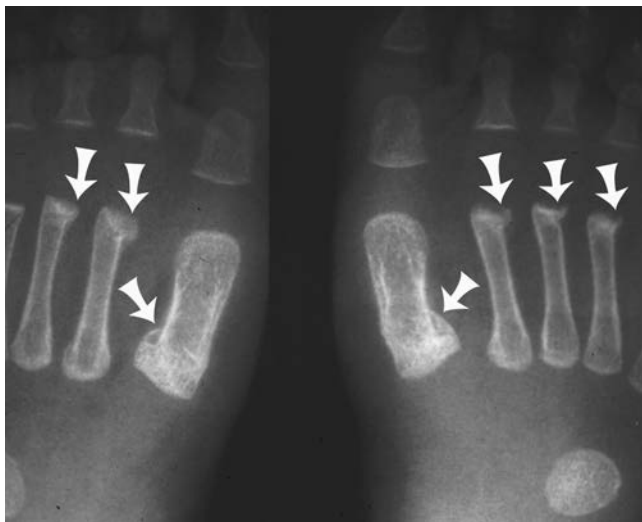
Metatarsal fractures in a 2-month-old female victim of nonaccidental trauma. Radiographic image from a skeletal survey shows multiple healing, bilateral, and symmetric proximal and distal metatarsal fractures (arrows).
